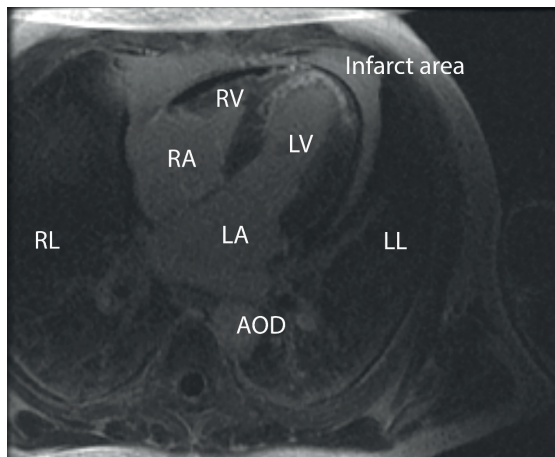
An MRI (late gadolinium enhancement) image of a patient with acute myocardial infarction. Notice the hyperenhanced, bright signal of the left ventricular muscle. The black areas are associated with obstruction of the small vessels. Abbreviations: RL: right lung, LL: left lung, RV: right ventricle, LV: left ventricle, RA: right atrium, LA: left atrium, Aod: descending aorta.
